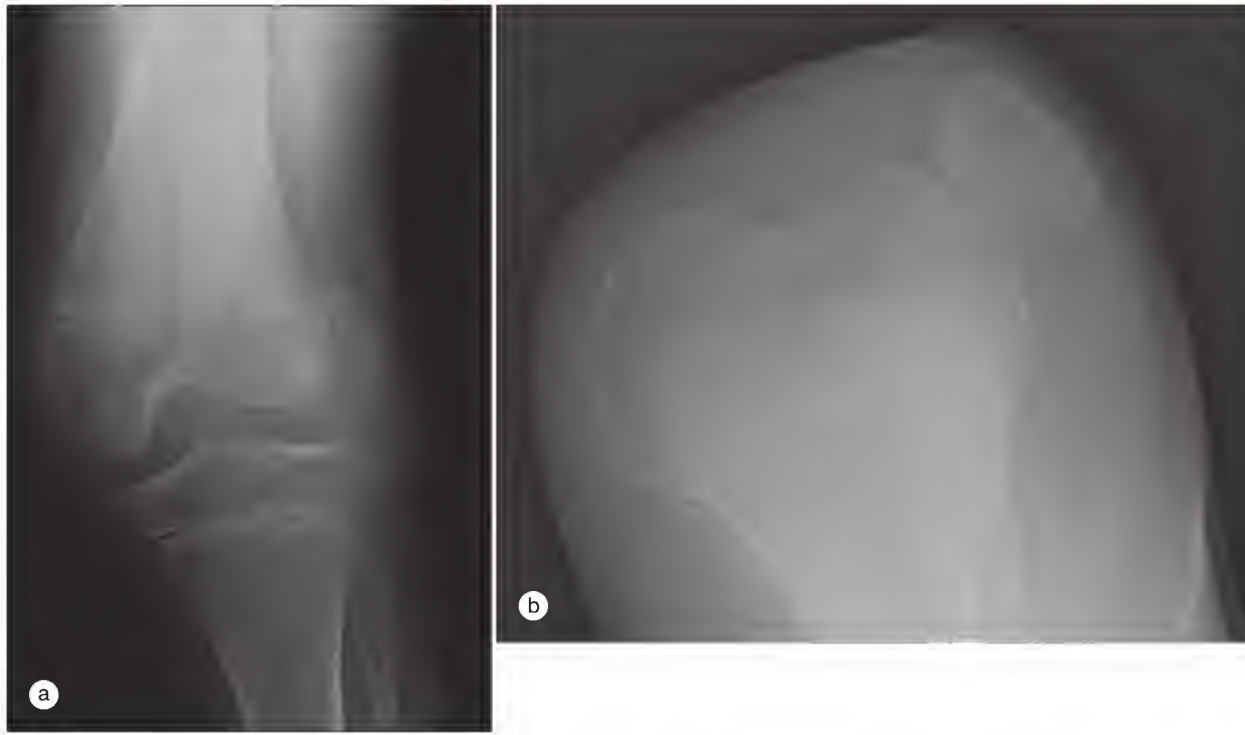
Anteroposterior (a) and skyline (b) radiographs showing patellar dislocation.
